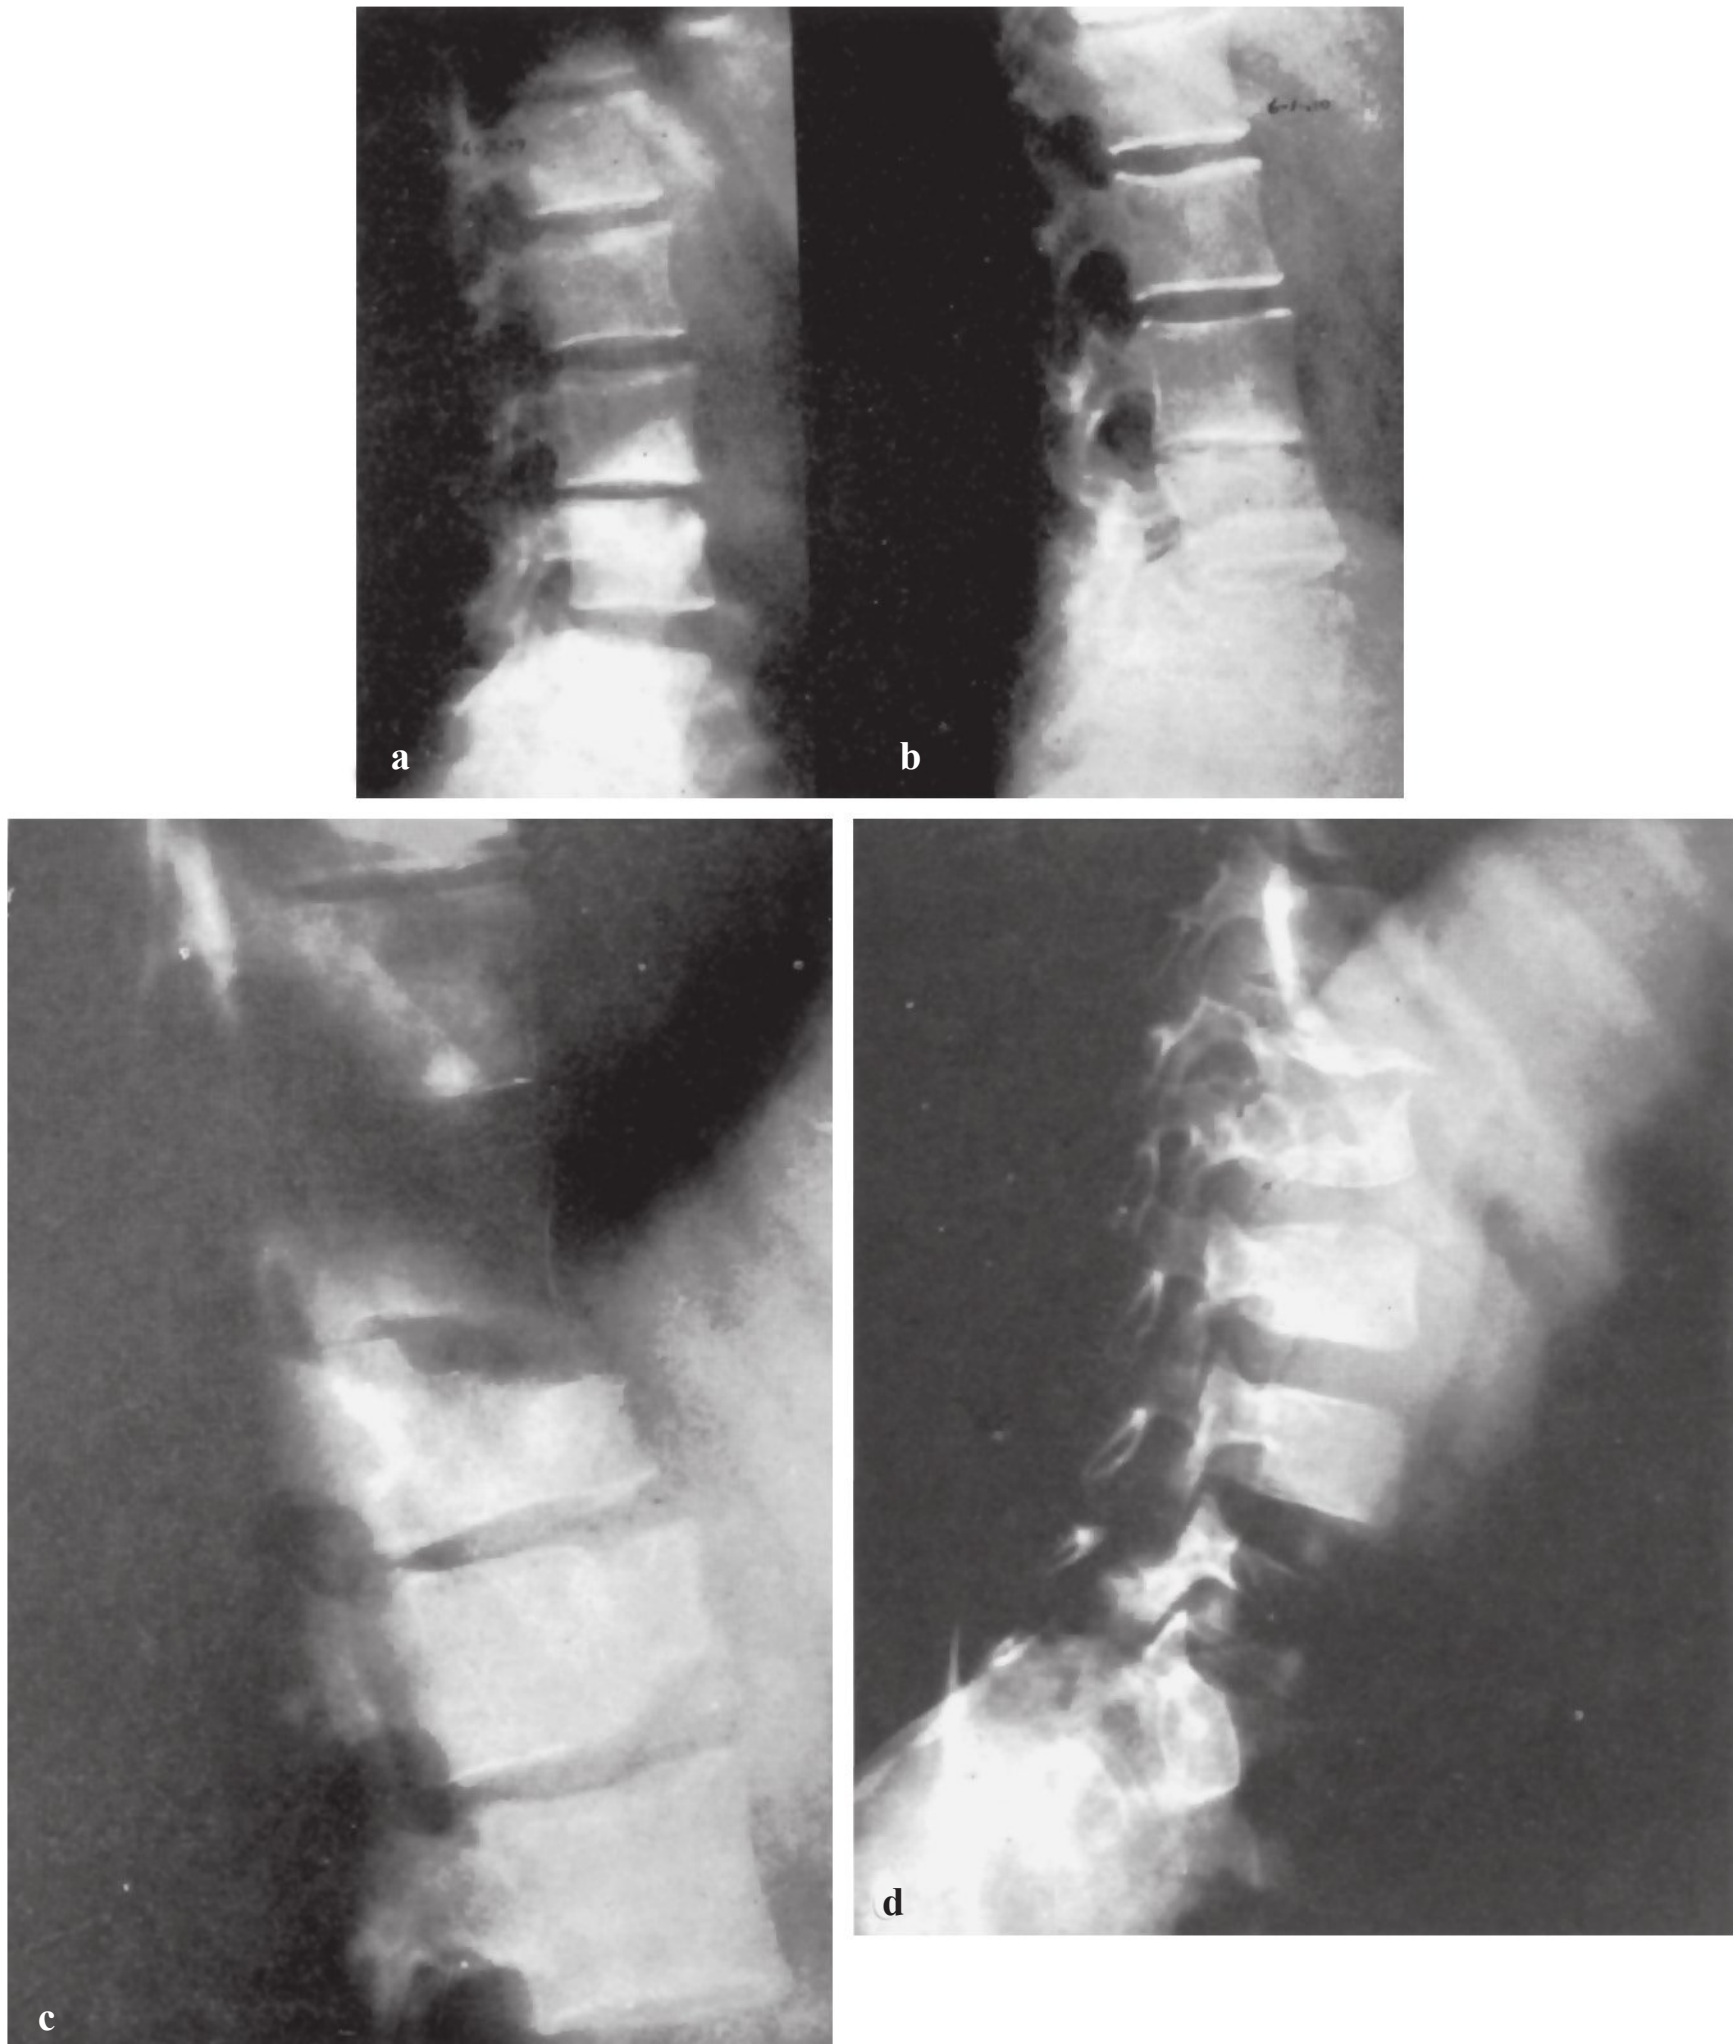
Radiographic features of the three types of tuberculous spondylitis. (a,b) Peridiskal involvement is characterized by disk-space narrowing followed by variable bone destruction. The radiograph on the left is early in the disease. The radiograph on the right is after resolution of the disease with minor deformity. (c) Anterior multilevel disease is distinguished by scalloped erosions of the anterior aspect of several adjacent vertebrae (T11, T12, L1). (d) Central involvement resembles a tumor with central body rarefaction and bone destruction followed by collapse (L1 and L2).
